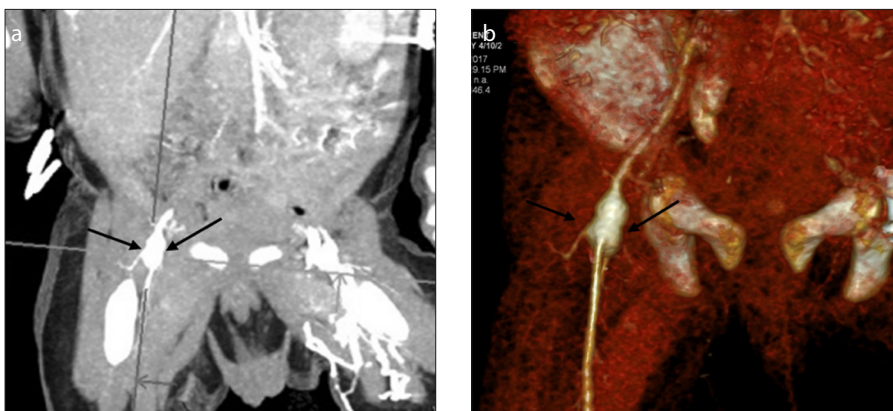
a, b. A right femoral artery aneurysm in a 4-month-old male patient with fever and bilateral conjunctival injection. Coronal MIP CT angiogram (a) shows a right femoral artery aneurysm (arrows). Anterior 3D volume-rendered CT image (b) shows a right femoral artery aneurysm (arrows).
